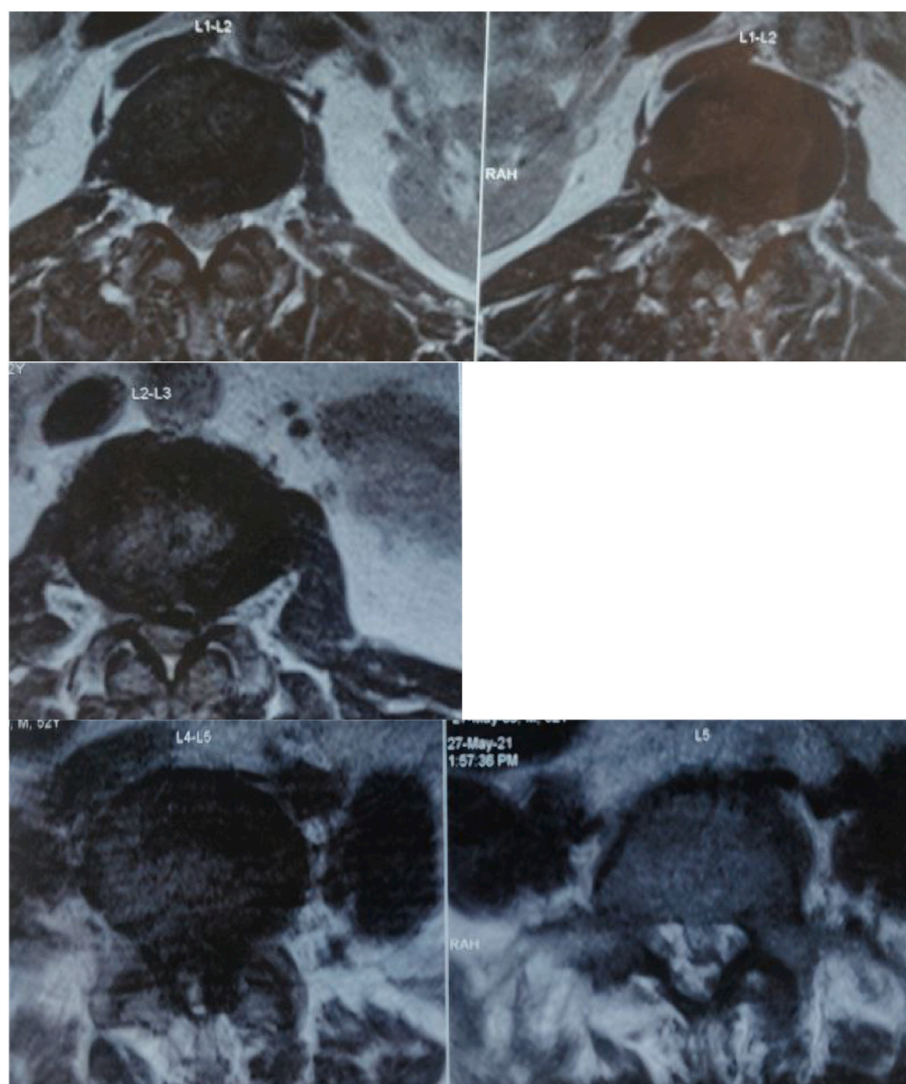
Axial images of L1-2 and L2-L3 show canal stenosis with compression of the exiting nerve root. Axial MRI of L4-5 showing beak-like left posterolateral extrusion of disc fragment protruding into the dural sac occupying most of the canal diameter at L4-5 level (hawk-beak sign).
